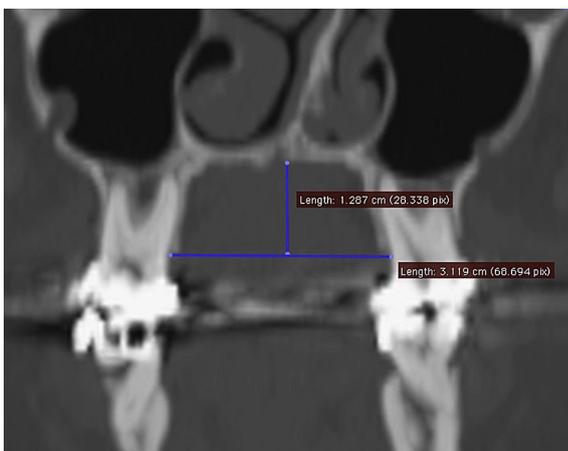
Computed tomographic section showing the measurement of the transverse distance between the molars (at the height of alveolar bone) and of palate depth.
